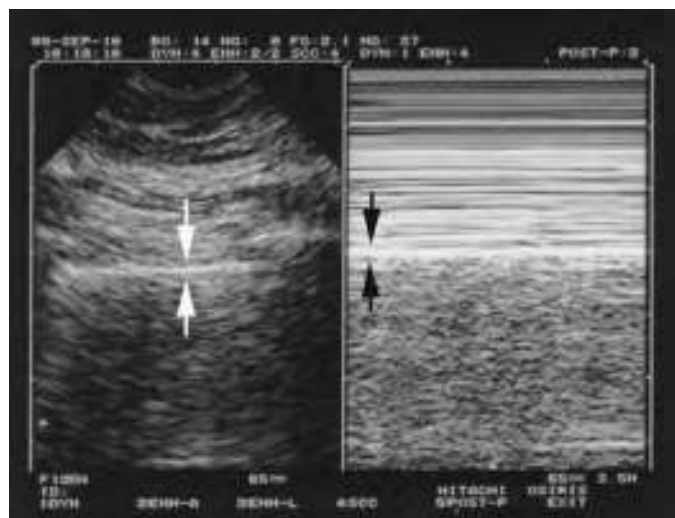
The sliding lung or seashore sign. Real-time US (*left*) and M-mode Doppler US (*right*). The *arrows* are the pleural interface. (Used with permission from reference 32.)
